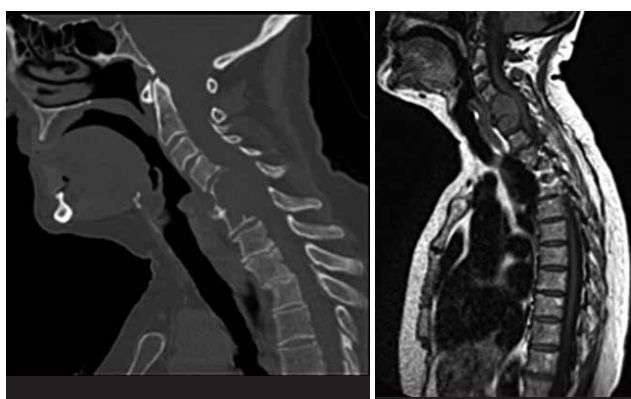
Pre-operative sagittal and axial CT of patient with multiple myeloma (patient 4). The SINS score was 12 – indeterminate instability.
